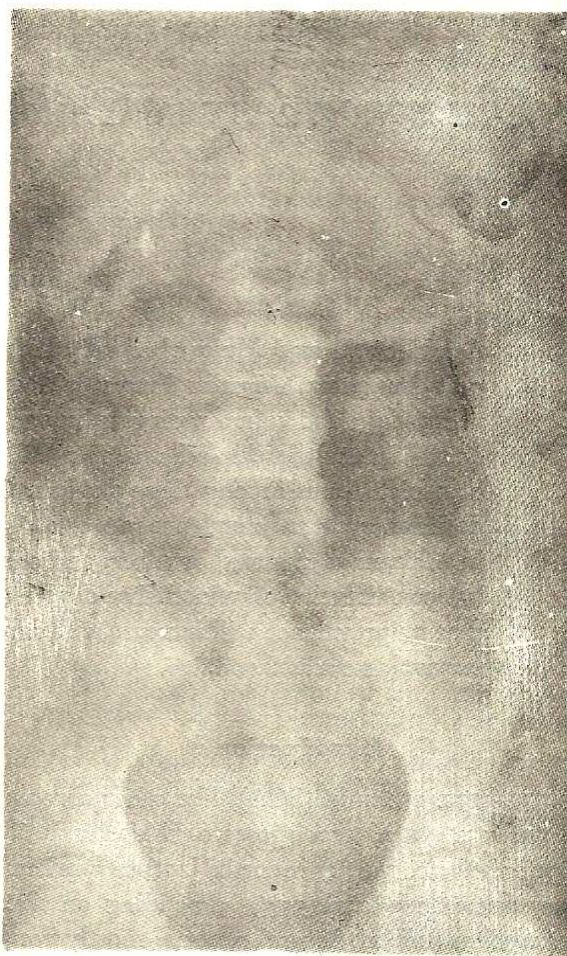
A plain abdominal radiograph showing a round opacity in the right hypochondrium. Oral cholecystography confirmed the opacity to be a gallstone.
